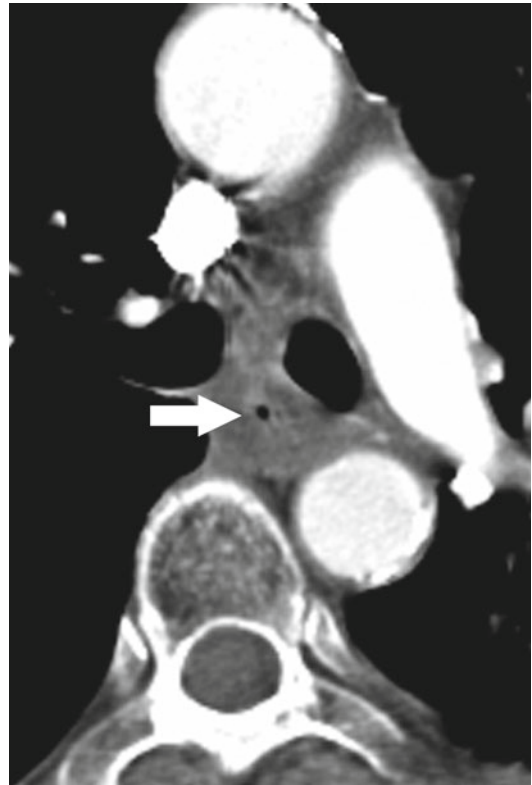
Radiation esophagitis following mediastinal radiation for lung carcinoma. Contrast-enhanced CT image shows marked esophageal mural thickening with luminal narrowing (*arrow*)
